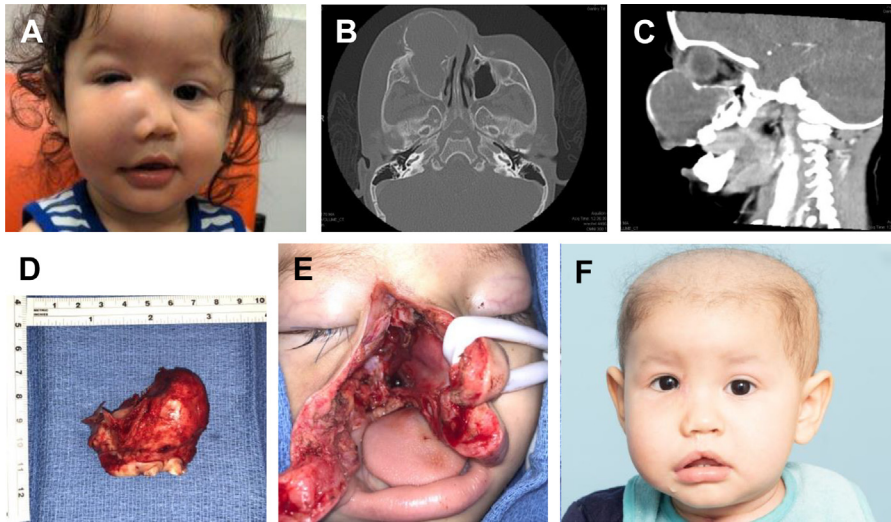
Maxilla. (A) Preoperative photo. (B) Axial bone CT scan with large right maxillary tumor. (C) Sagittal soft tissue CT scan with large right maxillary tumor exerting inferior pressure on the globe. (D) Tumor extirpation. (E) Intraoperative surgical defect. (F) One-month postoperative photo.
